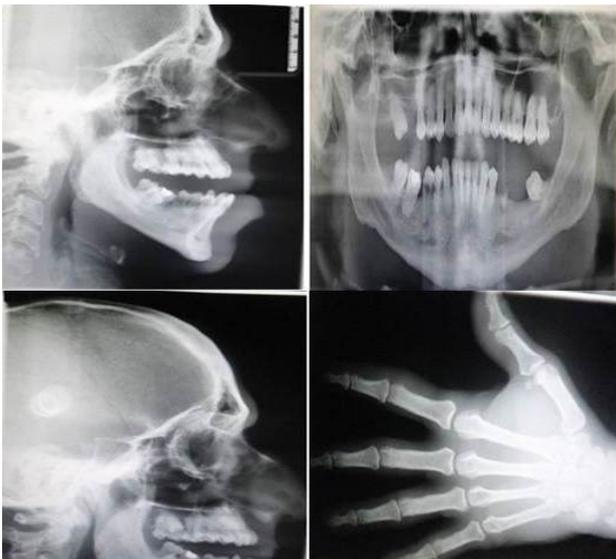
2 - Orthopantomograph, skull view in Acromegaly
